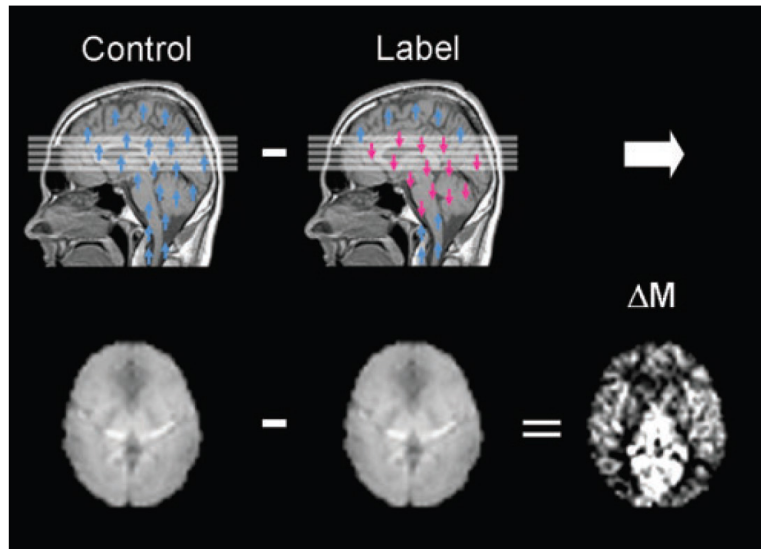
demonstrates how the subtraction of MR images with and without labeling yields perfusion-weighted images. Both the control and label images contain the positive magnetization of static brain tissue (blue arrows), whereas only the label image contains the negative magnetization of labeled blood (red arrows). Since the majority of the brain volume is composed of brain tissue, the control and label images themselves will appear as low resolution anatomical images, whereas the subtraction image (ΔM) is weighted for the magnetization difference between the control and label images, hence for perfusion.
